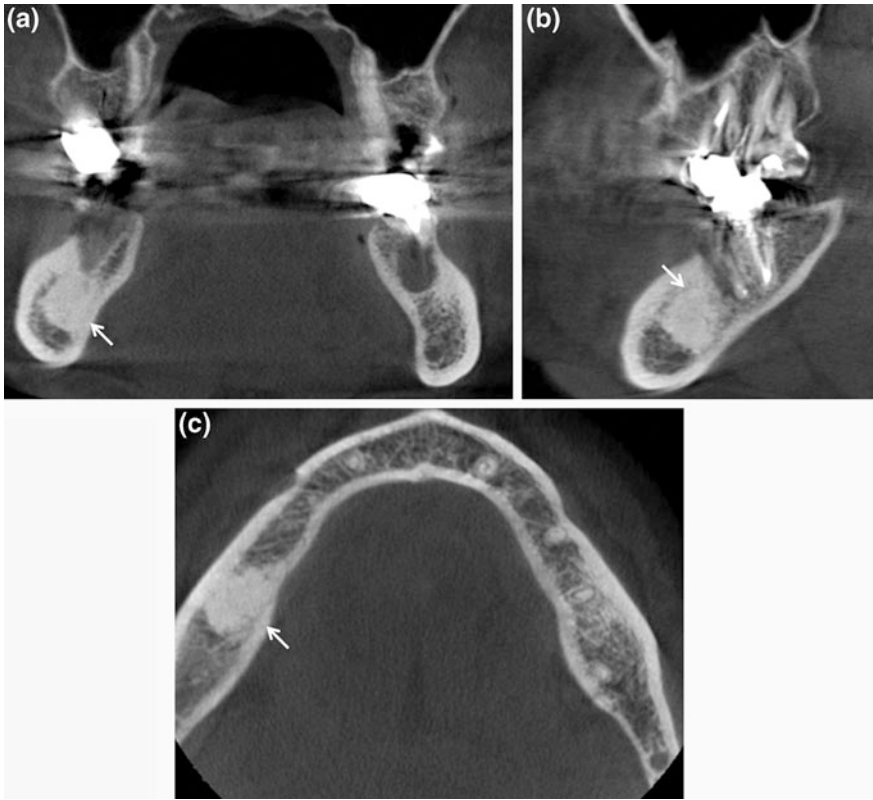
CBCT coronal (a), sagittal (b) and axial (c) scans demonstrating, in the right posterior mandible, at the site of 46 extracted, a bone sclerosis that confirms the diagnosis of condensant osteitis (*thin arrow*)
